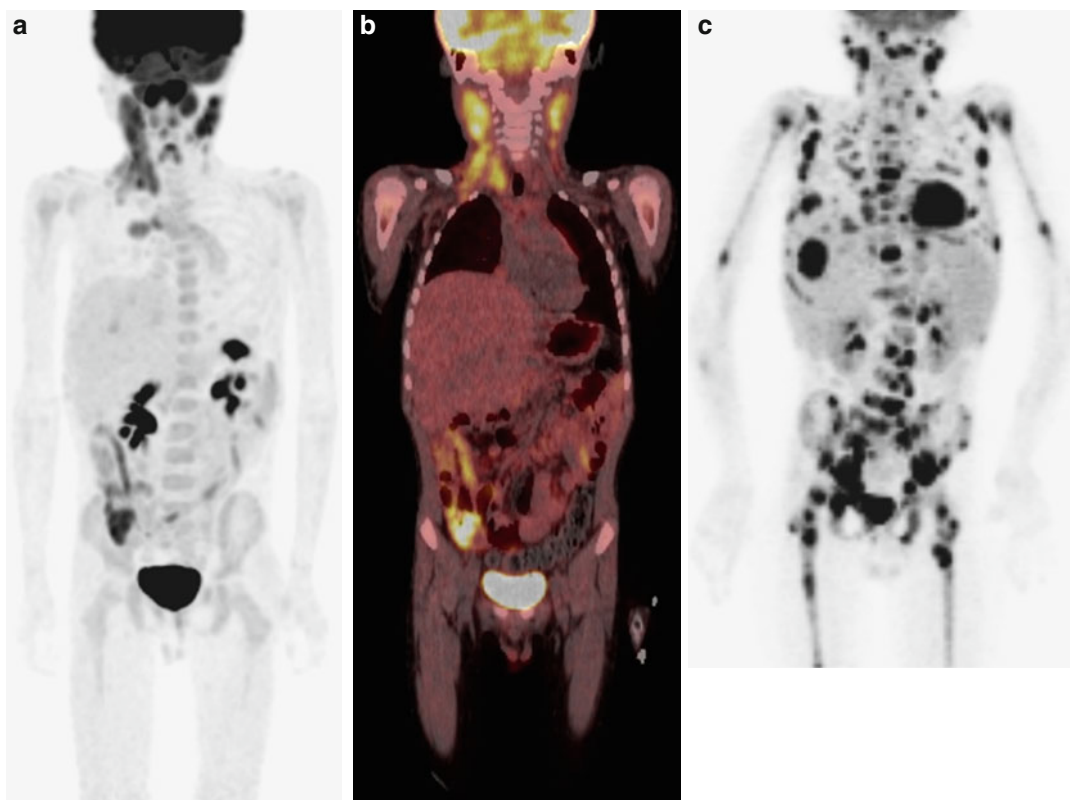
^{18}F -FDG PET/CT evaluation of lymphoproliferative disorders in patients with immune deficiency. (a) Three years after liver transplant for biliary atresia, an 8-year-old boy developed lymphadenopathy. Cervical lymph node biopsy demonstrated polyclonal posttransplant lymphoproliferative disorder. An MIP of an ^{18}F -FDG PET demonstrates FDG-avid disease involving cervical, supraclavicular, internal mammary, and cardiophrenic lymph nodes and focal FDG uptake in the right lower quadrant. (b) Co-registration of coronal ^{18}F -FDG PET and CT images confirms FDG-avid
